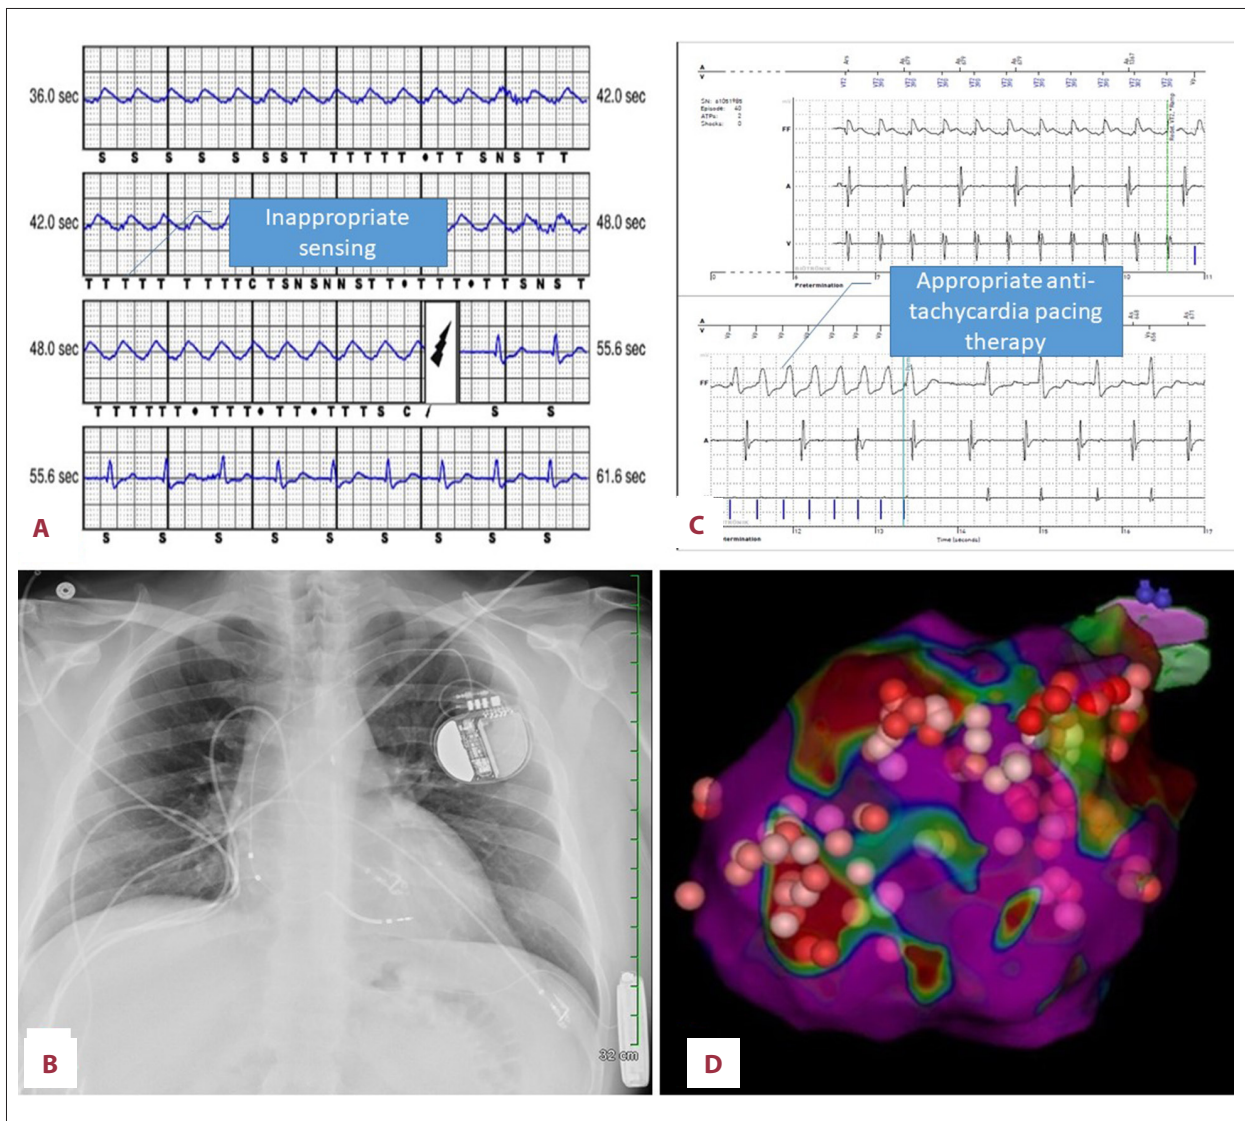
(A) Subcutaneous implantable cardioverter defibrillator (S-ICD) interrogation showing inappropriate T-wave oversensing leading to appropriate shock by the device. (B) Chest X-ray prior to S-ICD removal showing newly implanted transvenous implantable cardioverter defibrillator (TV-ICD). (C) TV-ICD with appropriate sensing leading to appropriate therapy. (D) Electroanatomic map of left ventricle in left lateral view showing ablation points in basal to mid anterolateral wall.
